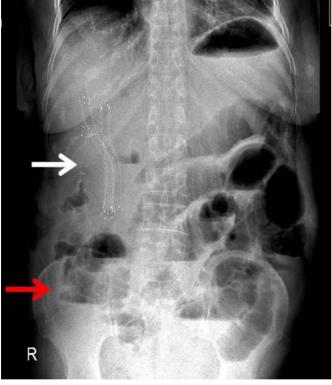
Abdominal X-ray showing previously placed biliary metallic stents (black arrow) and multiple air–fluid levels (red arrow).
